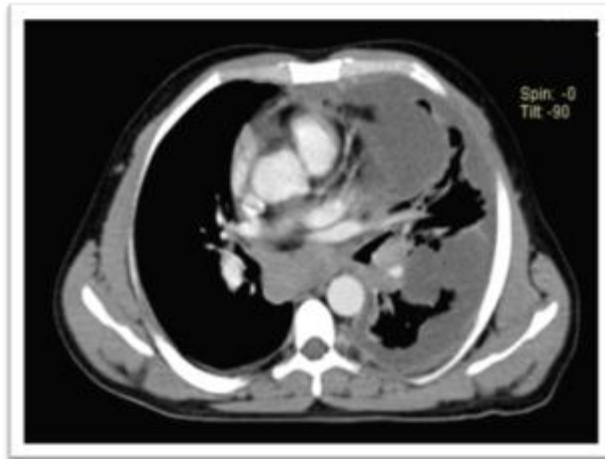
Axial contrast enhanced CT showing Lt sided circumferential pleural thickening involving all pleural surfaces with fissural extension and abutting the aorta.
